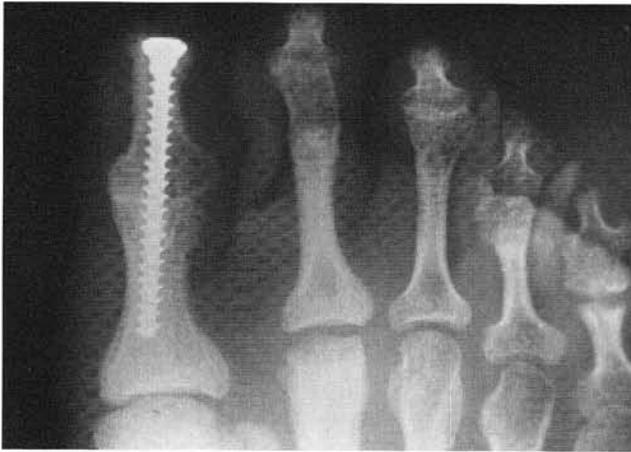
Postoperative radiograph using the fully-threaded cancellous screw.
